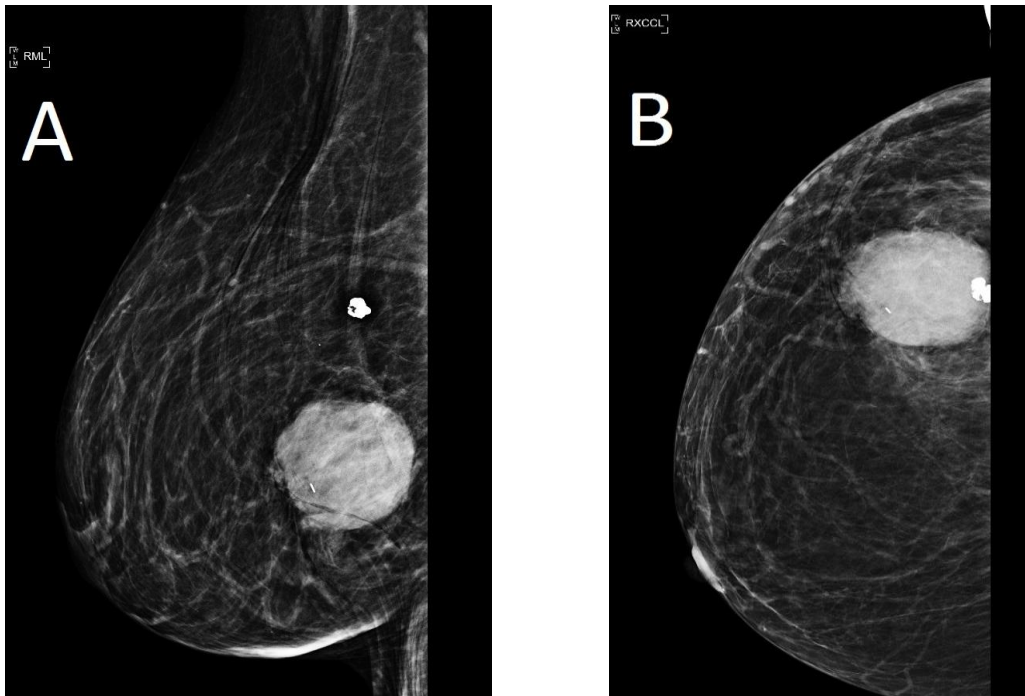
and Fig 3b: Right diagnostic mammogram performed after the ultrasound guided biopsy of the breast mass showing the round mass at the 8:00 location containing a biopsy clip.
